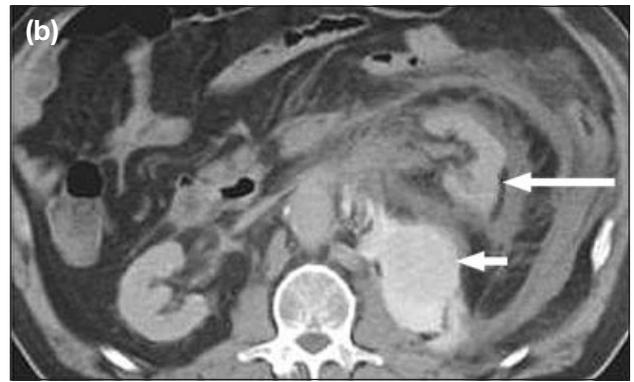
Ruptured aortic aneurysm causing a large retroperitoneal bleed. (a) Axial computed tomography scan shows an aortic aneurysm (asterisk) and vascular contrast material extravasation (short arrow) within a mural thrombus extending into a large left retroperitoneal haematoma (long arrow); and (b) axial computed tomography scan obtained superior to (a) shows vascular contrast material extravasation (short arrow) within a large left retroperitoneal haematoma displacing the left kidney anteriorly (large arrow).
